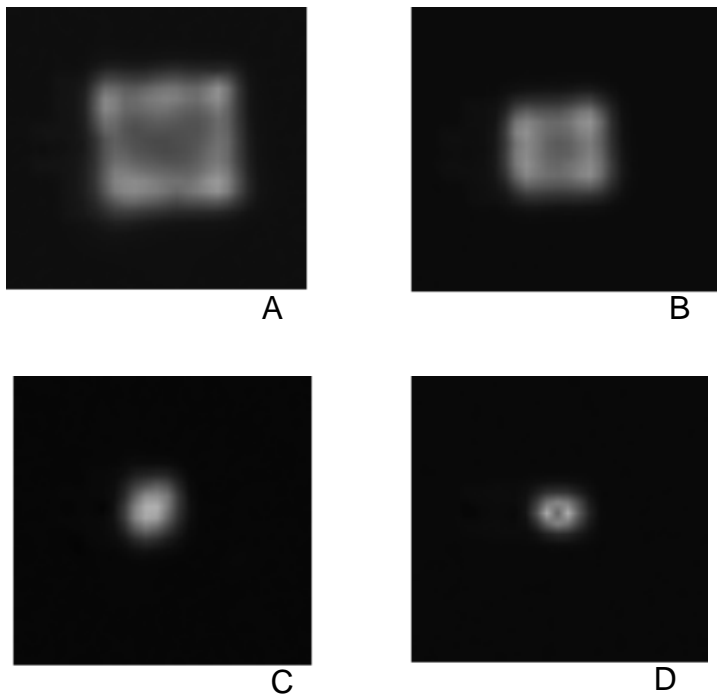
Reconstructed SPECT images obtained with Flash 3D and TEW-CT correction method, (A) Tumour I, (B) Tumour II, (C) Tumour III and (D) tumour IV.
